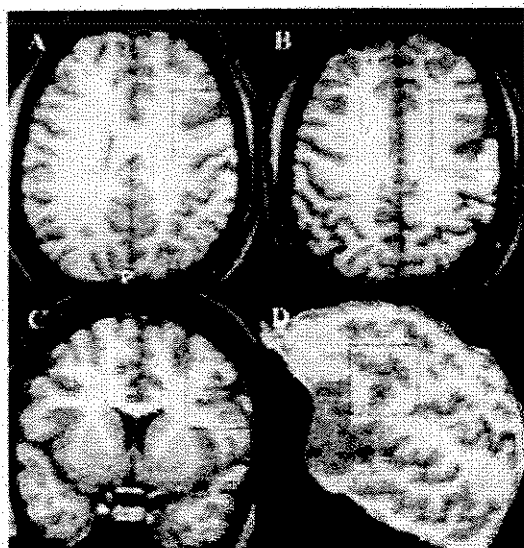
Patient 12. T1-weighted images show the same lesion in different planes (boxes). (A, B) Axial images in different planes of section, (C) coronal, and (D) curvilinear reformatting at 16 mm of depth from the cortical surface show the dysplastic lesion in the left frontal lobe (box). Note the cortical thickening, blurring between gray and white matter, and focal atrophy adjacent to the lesion, which can be identified on different planes (A, B, and C), suggesting that the cortical thickening is not the result of an oblique plane of section in relation to the gyrus or volume averaging.
